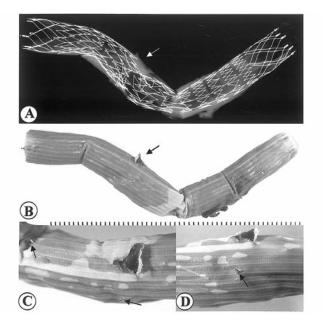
Postmortem radiograph (A) and gross photographs (B to D) of an endograft with fractured stent struts causing tears in the overlying Dacron graft with thrombus formation (arrow in B). Note there were multiple sites of protruded stent struts resulting in graft tears (C low and D higher power).
